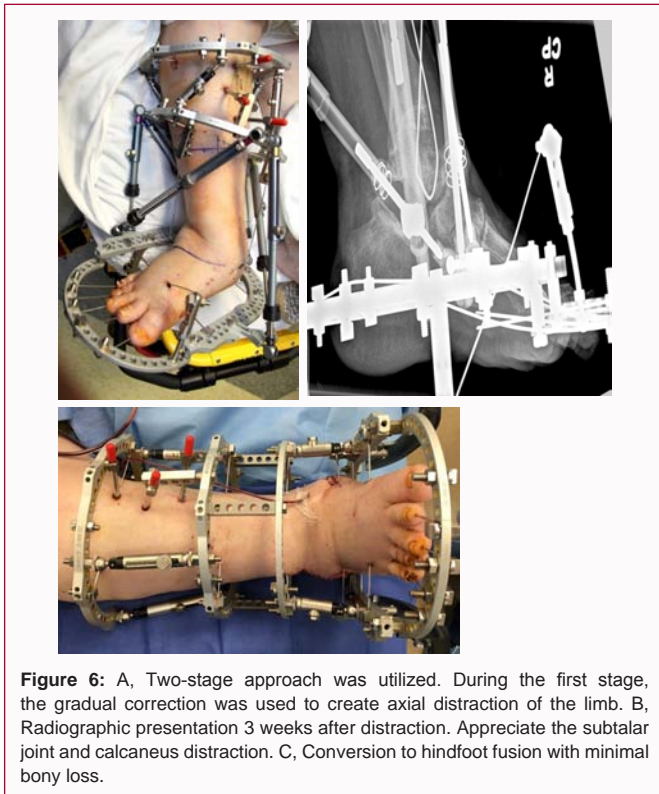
A, Two-stage approach was utilized. During the first stage, the gradual correction was used to create axial distraction of the limb. B, Radiographic presentation 3 weeks after distraction. Appreciate the subtalar joint and calcaneus distraction. C, Conversion to hindfoot fusion with minimal bony loss.
